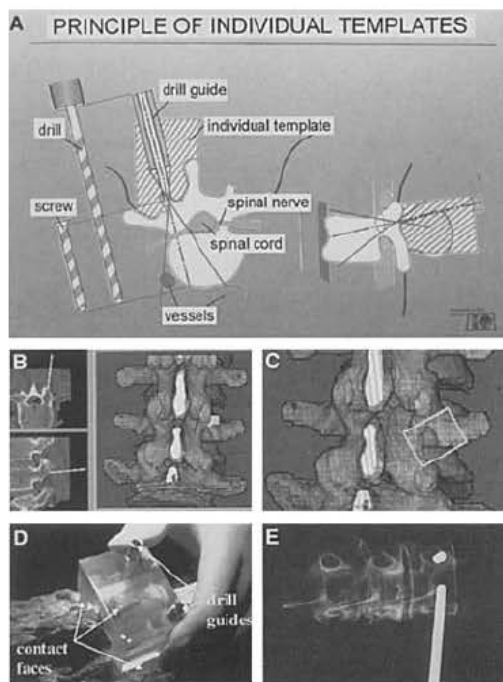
Pedicle screw placement: (A) the principle of individual templates based on preoperative CT imaging and computer based planning; (B) computer assisted planning of a pedicle screw placement with the DISOS planning system; (C) interactive specification of the reference contact face; (D) formclosed intraoperative fitting of the template; and (E) radiographic control of the placement of 5-mm rods in the pedicles without any perforation in situ.
